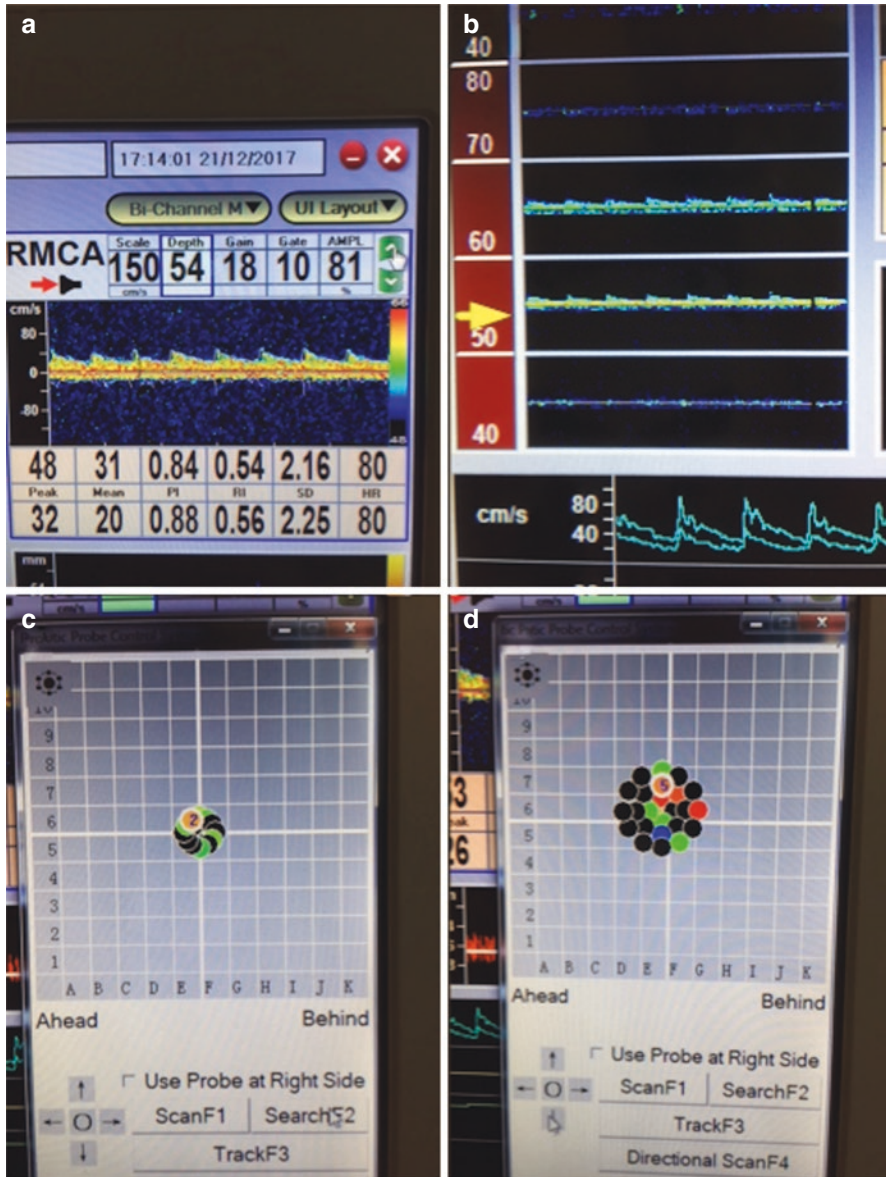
Example of Delica EMS 9D rTCD Monitor display during insonation and robotic adjustment. rTCD robotic transcranial Doppler. Panel (a) – cerebral blood flow velocity (CBFV) waveform for right middle cerebral artery, with peak, mean, pulsatility index, depth, gain and amplitude displayed on adjustable touch screen. Panel (b) – “look-ahead” view of CBFV. Panel (c) – Search robotic adjustment algorithm, insonating in spinal pattern about current probe center. Color coding indicates insonation CBFV intensity with black indicating no flow detected and yellow/red indicating moderate/good signal intensity. Panel (d) – Directional scan robotic adjustment algorithm. Insonates about current probe axis, changing insonation angle to optimize signal intensity. Again, red indicates good CBFV signal intensity. (Figure reproduced in color with author permission from Zeiler and Smielewski [12])
